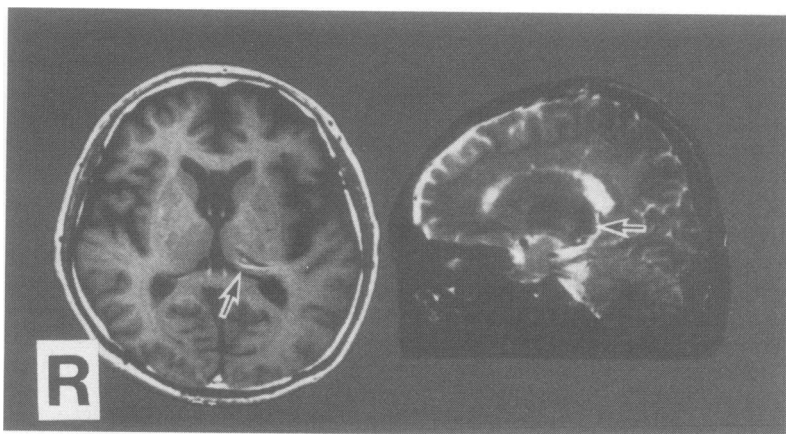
Left panel: T1-weighted axial MRI showing mixed intensity lesion (arrow) in the left pulvinar. Right panel: T2-weighted sagittal MRI showing low intensity lesion (arrow) in the left pulvinar.
